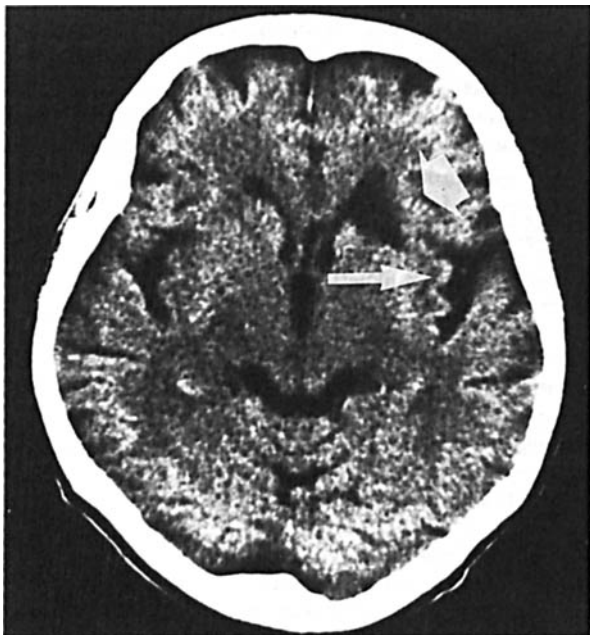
Cranial CT of patient 3: left frontal white matter infarction (broad arrow), left fronto-temporal cortical atrophy (slim arrow), and cerebellar cortical atrophy
